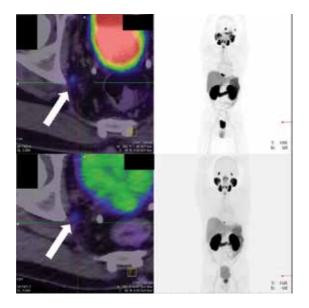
The PSMA PET scan demonstrates uptake of the tracer in an internal iliac node denoted by the white arrow.
